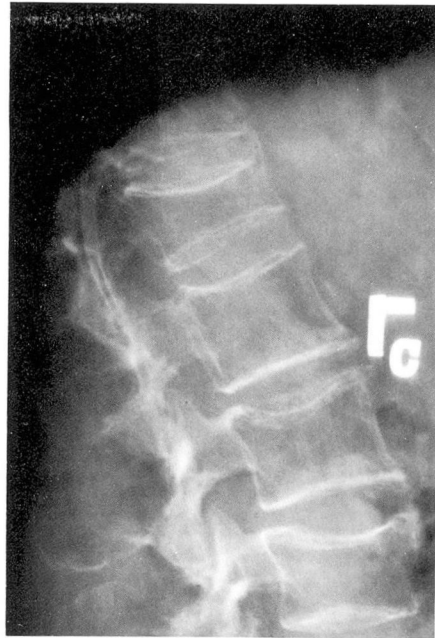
Roentgenogram, lumbar spine (case 28); moderately severe osteoporosis is identified.
